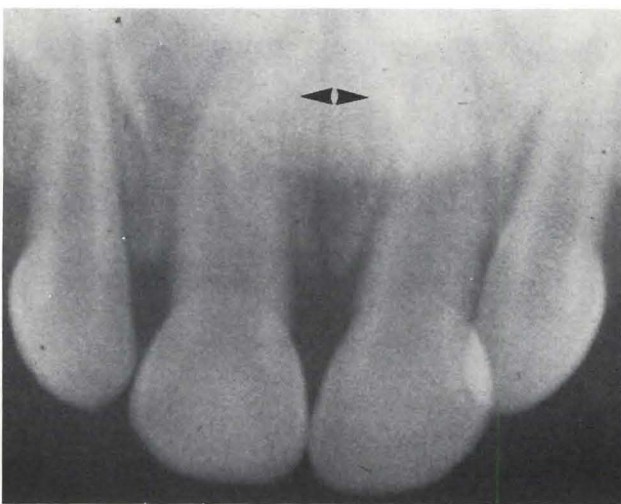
Periapical radiograph of maxillary central incisors showing widening of the periodontal ligaments.
